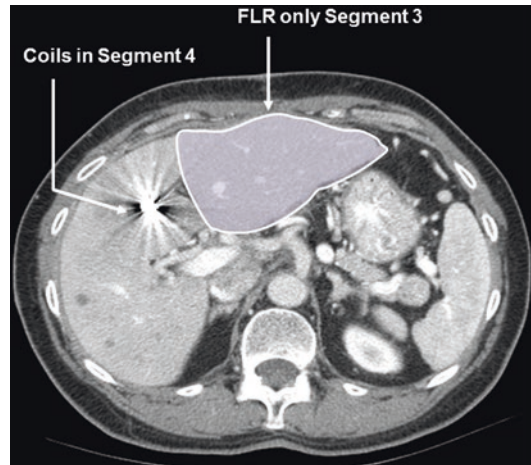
Contrast-enhanced CT 4 weeks after right PVE with segment 4 embolization. The latter caused atrophy of segment 4 and increased hypertrophy of the left lateral segments, which in this patient represented the future liver remnant (FLR)
